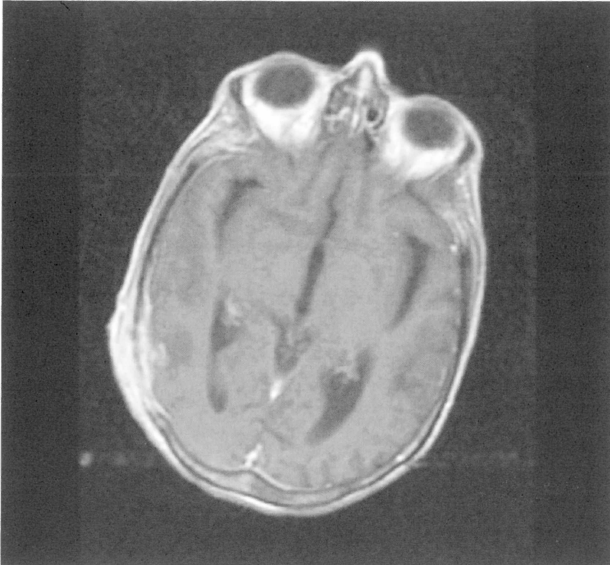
Transversal view of MRI showing diffuse meningeal enhancement.
